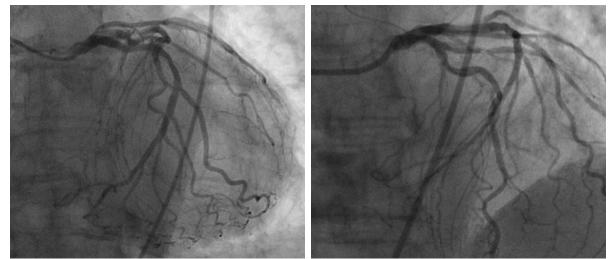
Due to overlap by the contrast agent of other vessels the coronary stenosis of a diagonal vessel is difficult to see on the left fluoroscopic image. With a gantry position of LAO 2° / CRAN 2° an optimal view is achieved as shown on the right image. This optimal view of the right image is predicted by the calculated tree model of figure 6 without the application of additional X-rays or contrast medium.
